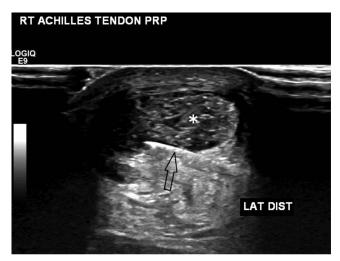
Sonographically guided PRP injection for Achilles tendinopathy with transducer in anatomic short axis view using an in-plane, lateral to medial, injection technique. Achilles tendon (asterisk), needle (open arrow).
